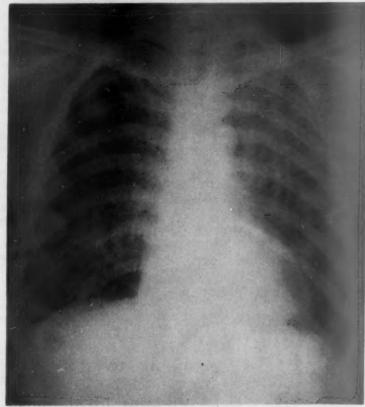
Case 2. Chest x-ray four months after onset of symptoms. Note miliary lesions, small right pleural effusion and cardiomegaly.
